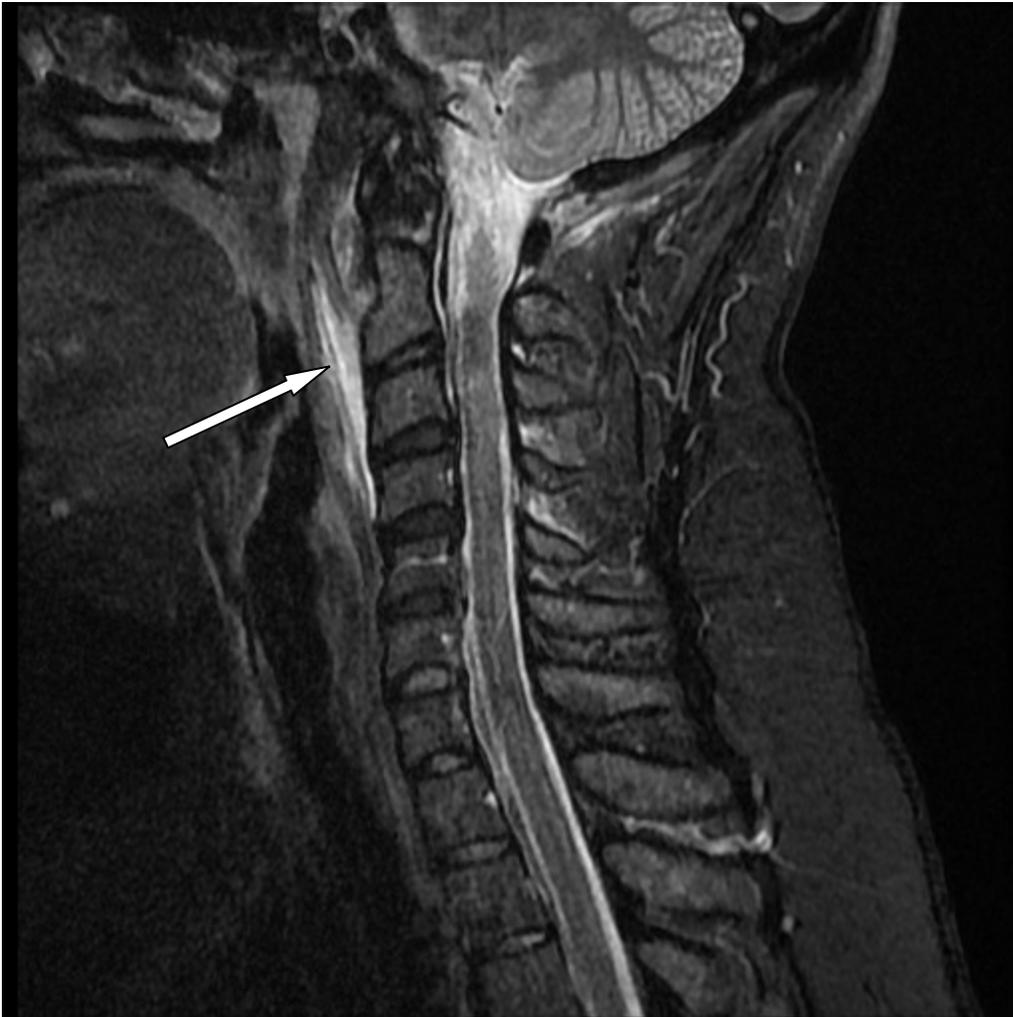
MRI neck Sagittal, short T1 inversion recovery (STIR) sequence image demonstrates inflammation of the Longus Colli tendon (arrow).
